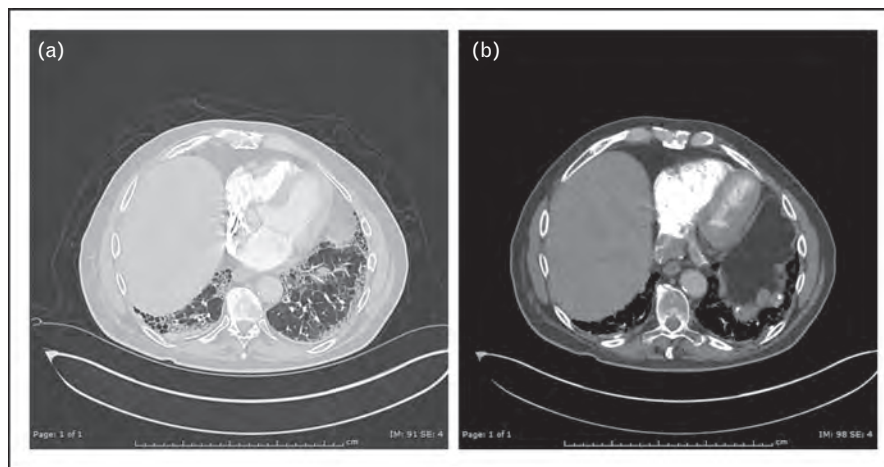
Asbestosis high-resolution chest CT scan. (a) HRCT lung windows demonstrate lower lobe predominant disease with evidence of reticular markings and honeycombing. (b) Mediastinal windows reveal evidence of pleural thickening and calcifications (Courtesy of Jonathan Killam, MD and Ami Rubinowitz, MD). CT, computed tomography.
